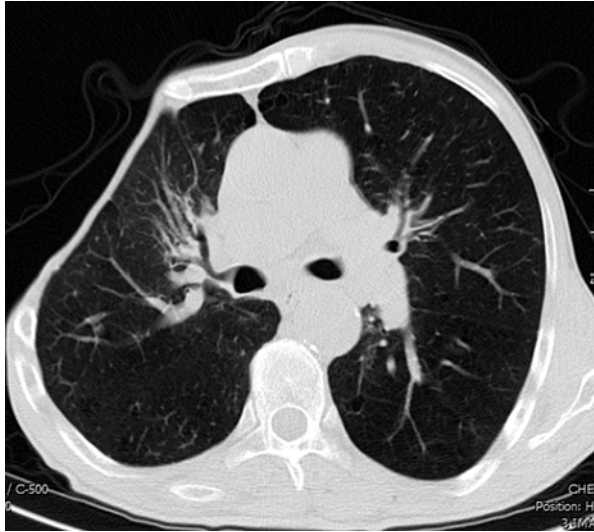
Chest computed tomography confirmed the asymmetry of the chest with absence of the pectoralis muscles and costal cartilage of ribs 3 through 5 on the right hemithorax
